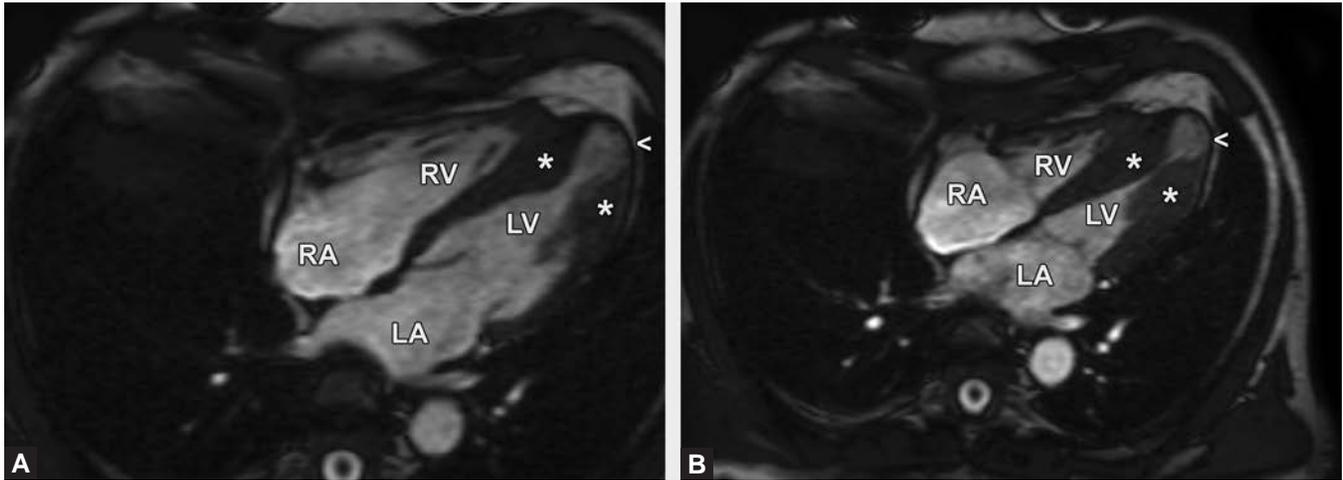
Apical 4-chamber view shows severe left ventricular hypertrophy (*) of the mid and apical segments.
